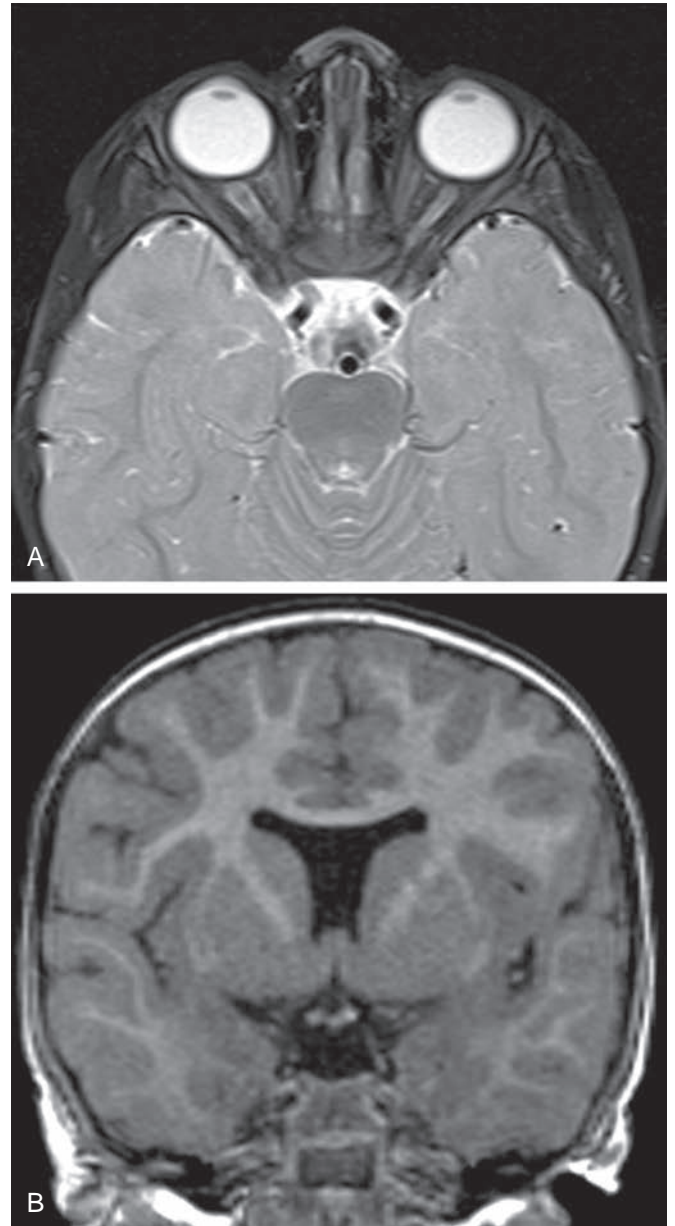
Optic nerve hypoplasia/septo-optic dysplasia. (A) Axial T2-weighted fat-saturated MRI of the orbits shows bilateral optic nerve hypoplasia. (B) Coronal T1-weighted MRI demonstrates an associated small chiasm and absent cavum septi pellucidi.
